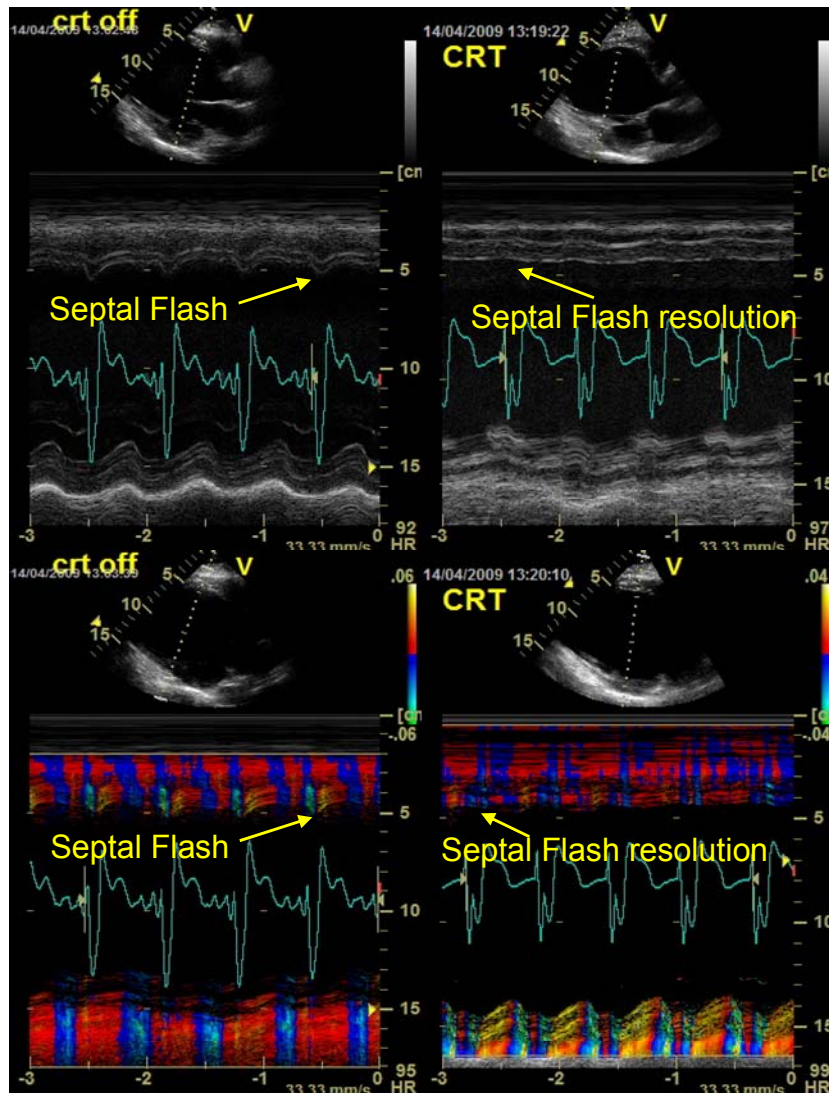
The septal flash i.e. the early septal thickening/thinning (occurring within the duration of the QRS complex), visualized on the parasternal long axis view using gray scale (top, left) or tissue Doppler color M-mode (bottom, left), imaged as a rapid change of color during the isovolumic contraction time. The resolution of the septal flash as seen immediately after CRT device implantation (top and bottom, right).
